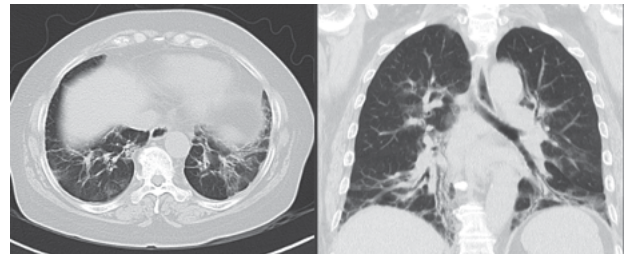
Chest CT axial and coronal views shows reticulation with architectural distortion, ground glass opacities and fibrotic bands in lower lung zones on follow up CT 2 years later.
